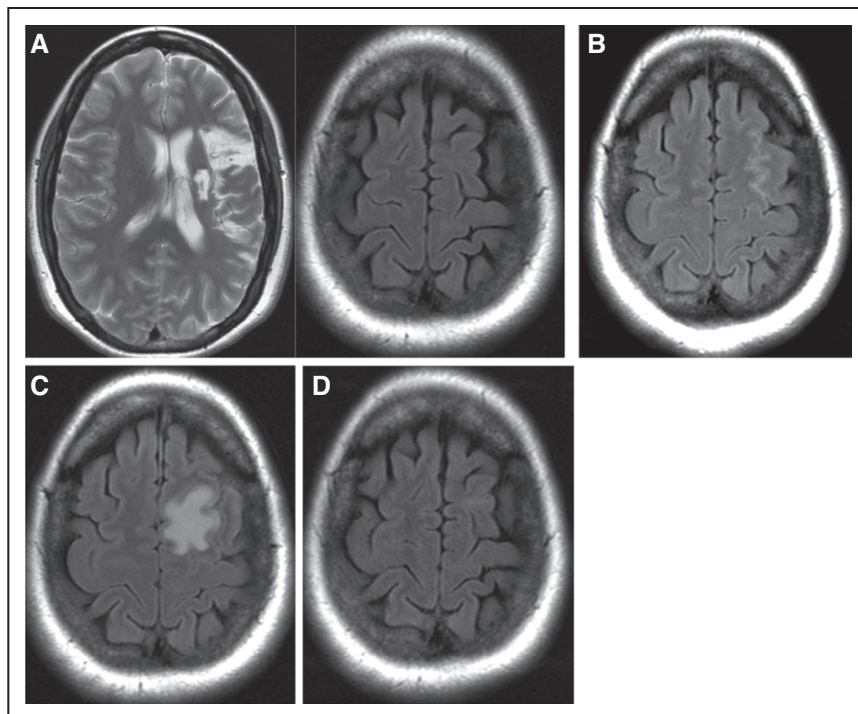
A–D, MR brain scans from a 39-year-old female patient, transplanted with SB623 cells 2 years after a left middle cerebral artery stroke. (A left) Axial T2 FSE pretransplant showing the subcortical and cortical infarct. (A right) Pretransplant at higher axial level. (B) Day 1 post-transplant at higher axial level demonstrating small amount of blood in left frontal sulci. (C) Day 7 post-transplant at higher axial level showing new T2 FLAIR signal abnormality in left superior frontal gyrus adjacent to premotor gyrus. (D) Month 2 post-transplant at higher axial level showing resolution of T2 FLAIR signal abnormality. FLAIR indicates fluid-attenuated inversion recovery; FSE, fast spin echo; and MR, magnetic resonance.
